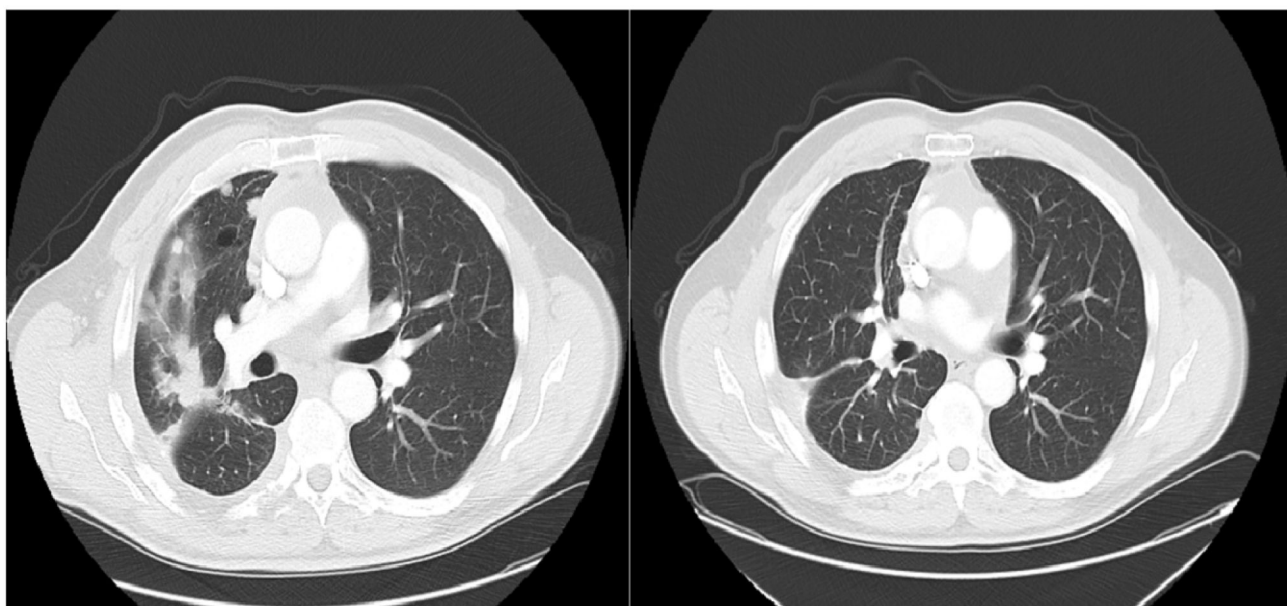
Radiographic Response in patient #1. CT scan for patient #1 at baseline (left panel) and after 14 months of capecitabine/celecoxib (right panel). The patient had a complete response, with complete resolution of his pulmonary metastases.
